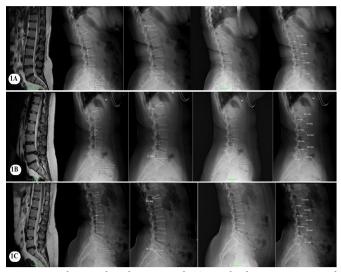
Photographs show sagittal T2-weighted MR images and morphometric measurements on lateral lumbar radiographs of healthy individuals (1A), individuals with L4-5 intervertebral disc herniation (1B), and individuals with L5-S1 intervertebral disc herniation (1C)
